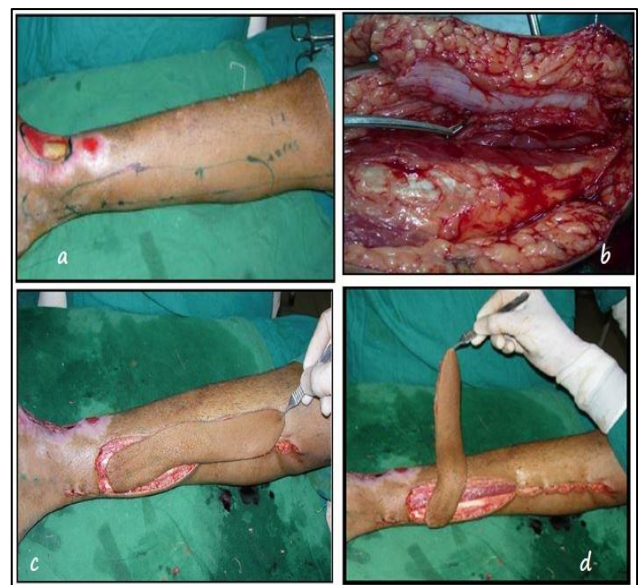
(A-D): A defect in the lower one third of leg, distally based PTAP flap marked with two perforators marked (x) adjacent to the defect with a hand-held Doppler; PTA perforator is shown with peri perforator dissection; PTAP flap islanded on the perforator is shown; PTAP flap rotated 160° in counter clock wise.
